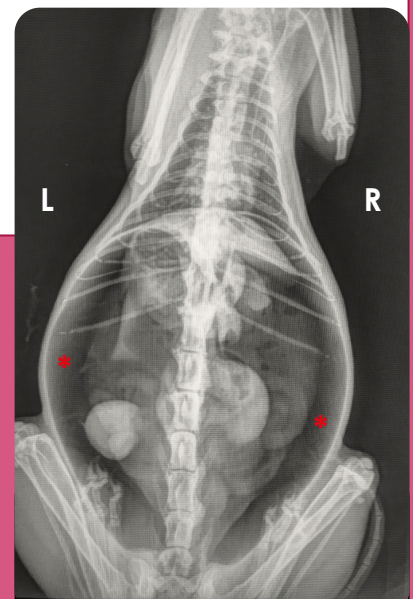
DV radiograph of the abdomen and thorax showing pneumoperitoneum (*)
